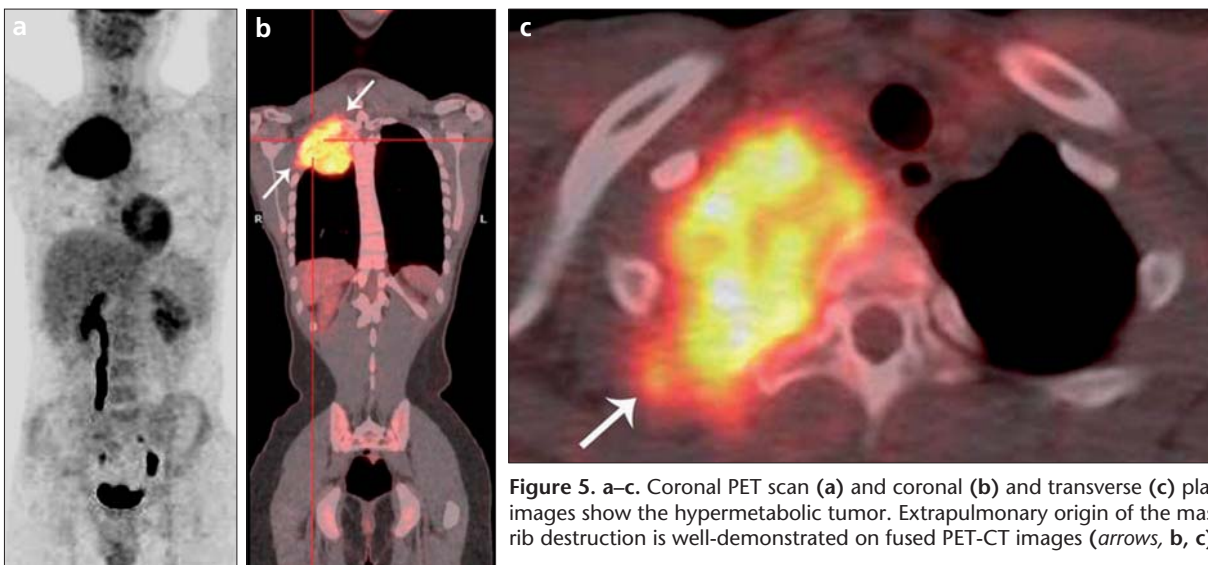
a–c. Coronal PET scan (a) and coronal (b) and transverse (c) plane fused PET-CT images show the hypermetabolic tumor. Extrapulmonary origin of the mass with posterior rib destruction is well-demonstrated on fused PET-CT images (arrows, b, c).
